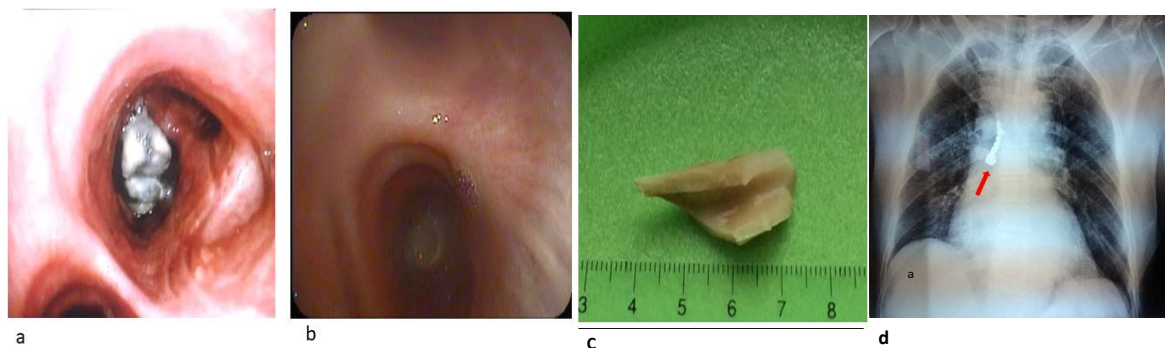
A, B) Endoscopic images of foreign bodies lodged in the bronchial tree, C) lamb bone removed from the third reported case, D) chest X-ray showing a radio-opaque aspirated foreign body (arrow).
